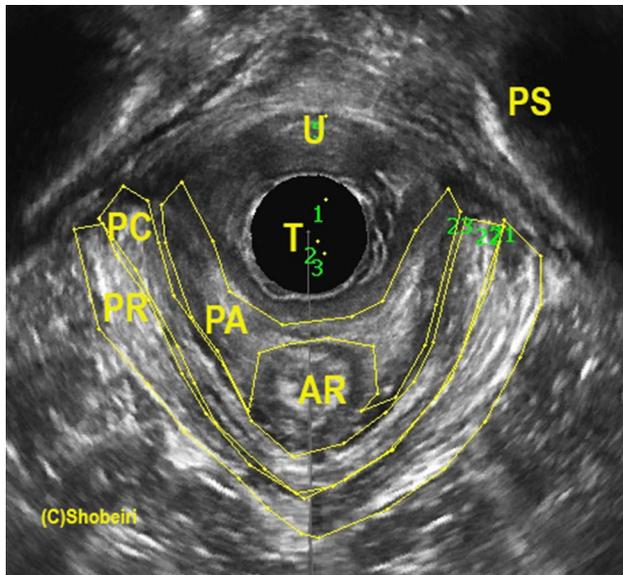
Axial view obtained with 3D endovaginal ultrasound demonstrating an intact pelvic floor highlighting the LAM subdivisions
